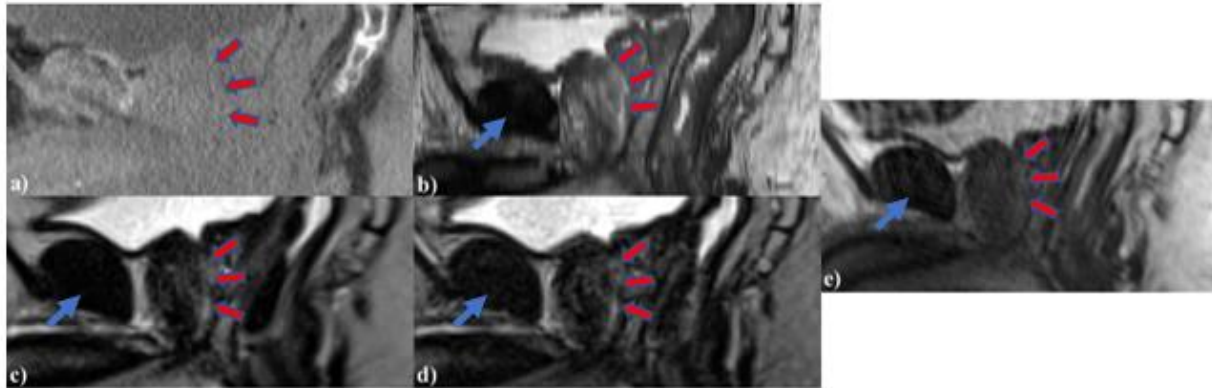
Patient 11's (a) planning CT, (b) 2D diagnostic T2w MRI at 3T, (c) MRgRT 3D HASTE, (d) MRgRT 3D TSE, and (e) clinical MRgRT 3D bSSFP (red arrows pointing to the prostatic urethra). Blue arrows showing different amounts of motion/ghosting artifacts in each MRI image. The clinical MRgRT 3D bSSFP showed significant motion/ghosting artifacts.
